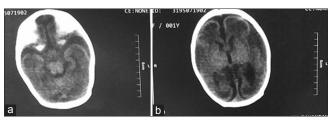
(a and b) Computed tomography scans of brain
